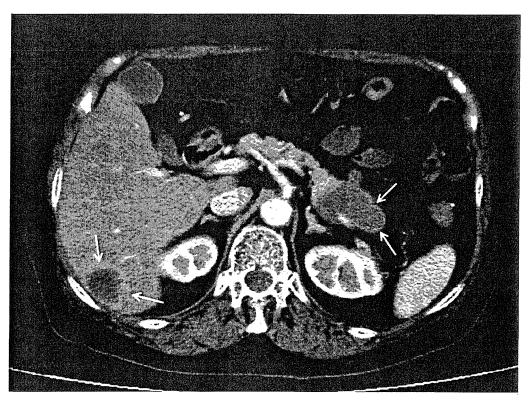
Low density lesion seen in the tail of the pancreas and segment 6 of the liver, metastatic tumor from the rectal carcinoma as imaged by contrast-enhanced CT scan.
